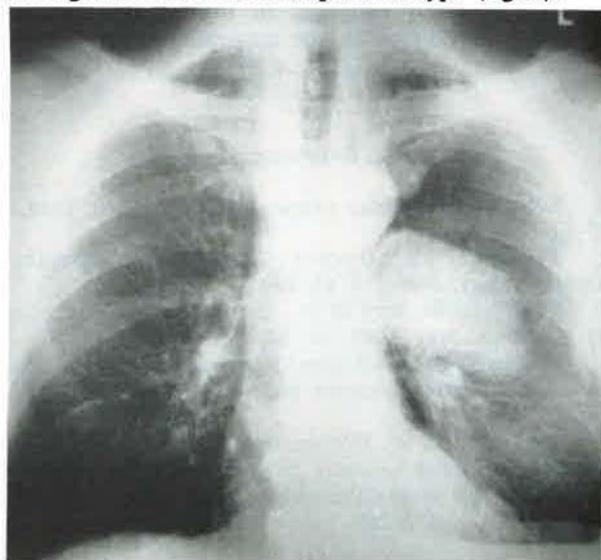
Chest PA roentgenogram: a large mass in connection with the left hilum with a small pneumothorax, a small mass in connection with the lateral chest wall, and a small pleural effusion. PA: posteroanterior.
